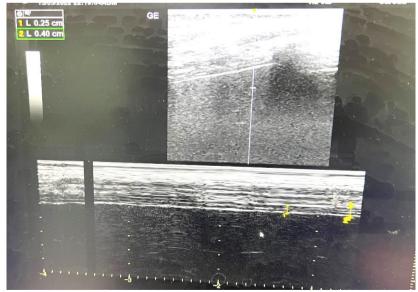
Measurement of diaphragmatic thickness by B-Mode and M-Mode ultrasound. A representative ultrasound image of a patient's diaphragm at end-expiration (1) and end-inspiration (2). The distance between the diaphragmatic pleura and peritoneal pleura (the two echoic lines)
